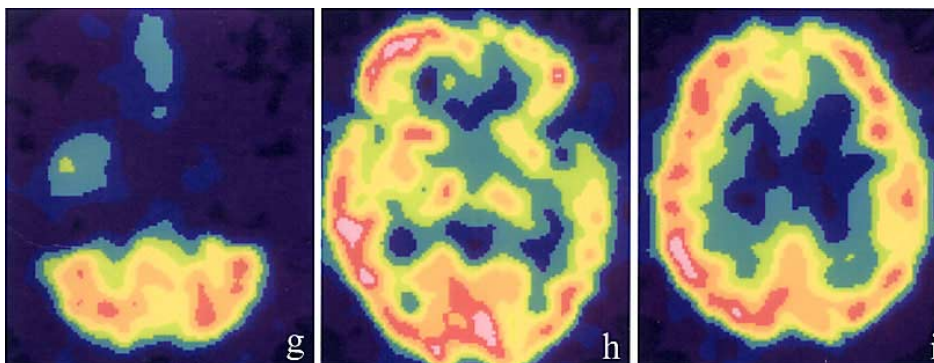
(g–i) SPECT images at three months after onset showed decreased uptake in the same areas where the second SPECT had shown increased uptake (Fig. 4).
